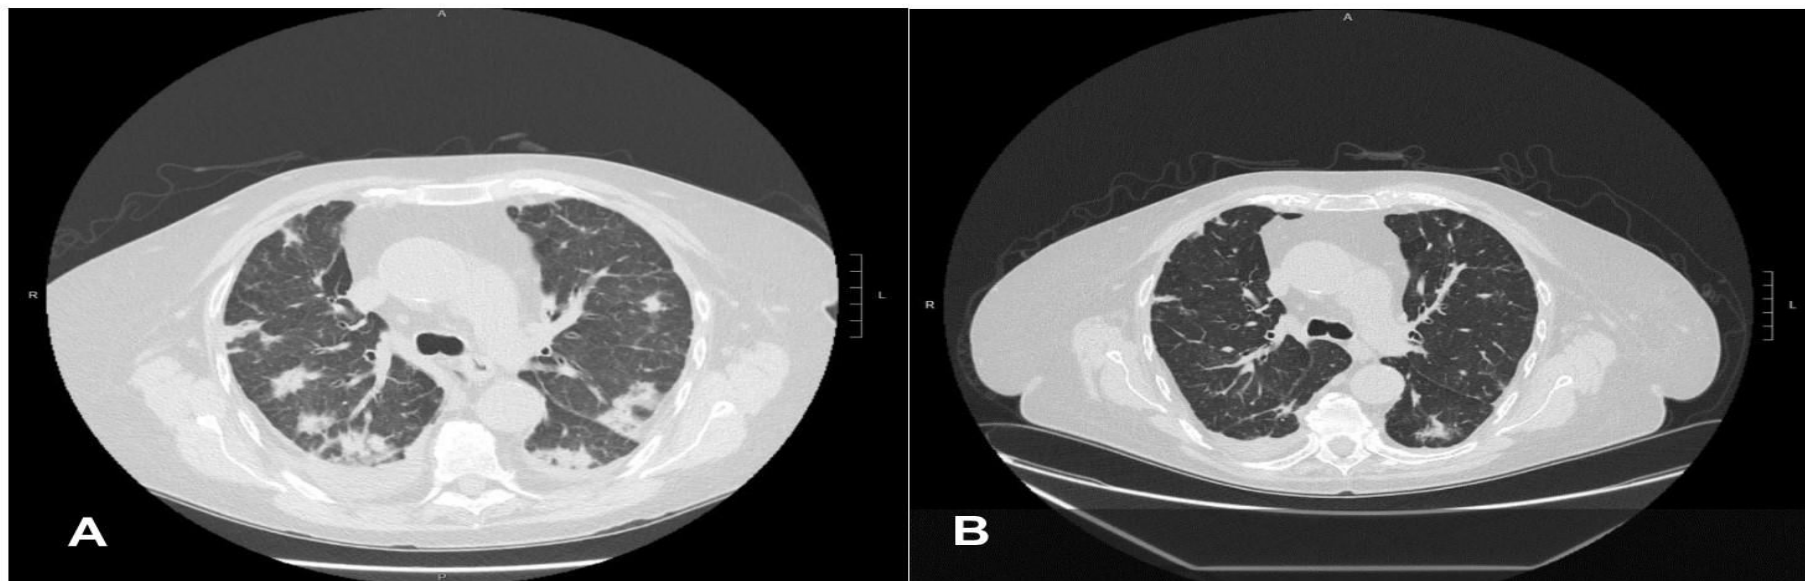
Figure A-B. Radiological finding in pulmonary nocardiosis: CT of the chest at the basal (A) and after XXI days of specific antibiotic therapy (B).
